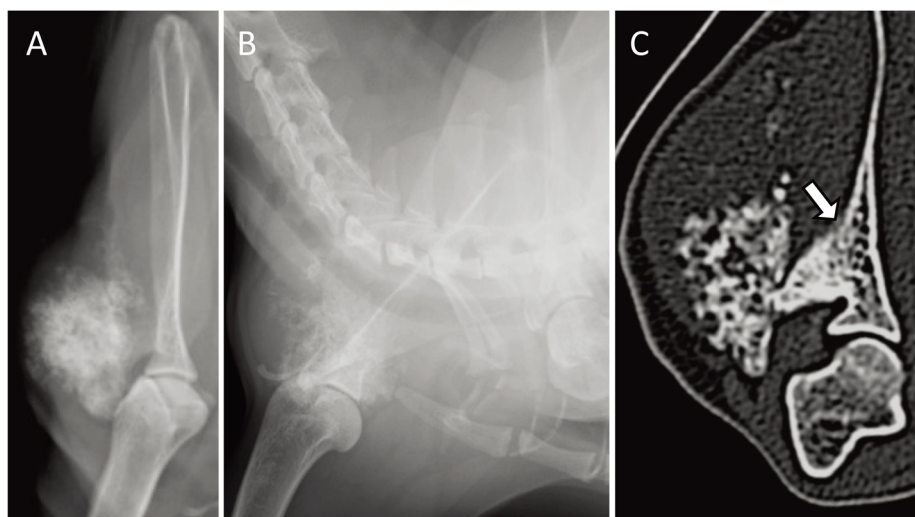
Lateral (A) and craniocaudal (B) radiographs of the right scapula with osteosarcoma at the initial visit; (C) Computed tomography reveals bone sclerosis (white arrow) proximal to the body of the scapula, and possible presence of tumor cells observed near the shoulder joint and proximal to the body of the scapula.
